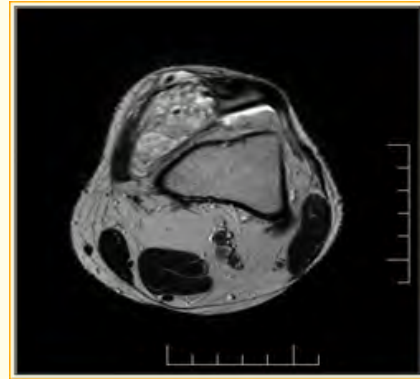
MRI left knee showing villous lipomatous proliferation of synovium showing high signal intensity on T2 weighted axial image with fluid collection.
